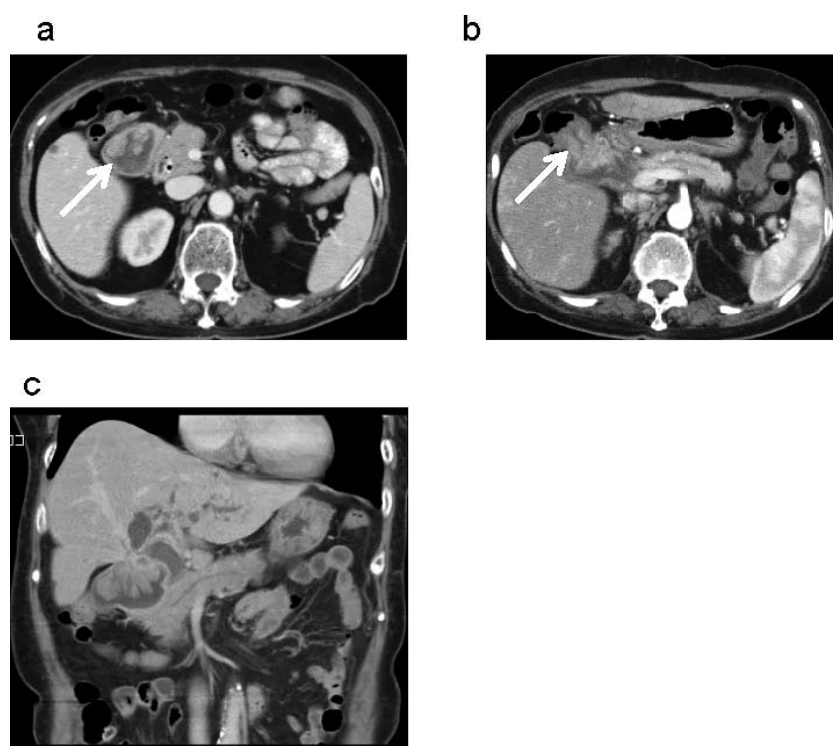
Abdominal enhanced CT findings. CT images were taken on the day of admission. Axial view (a and b) and coronal view (c). (a) Abdominal CT imaging revealed an enhanced tumor in the extended duodenum. The arrow on the figure indicates the duodenal carcinoma. (b) Invasion of the transverse colon was suspected. The arrow on the figure indicates the tumor invasion to the transverse colon. (c) Coronal view of the CT revealed invasion to the hilar bile duct and dilatation of the left hepatic bile duct and common bile duct.
